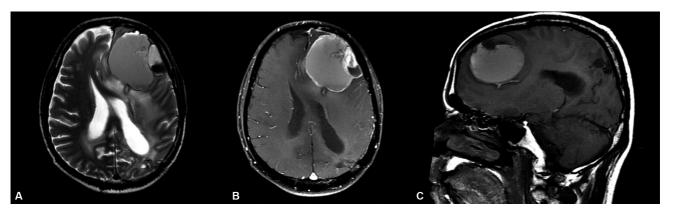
(A–C) Axial T2-weighted, post-contrast T1-weighted, and sagittal T1-weighted images post 4 weeks (on observation) showing an increase in the size of lesion and mass effect with cystic component now being T1 hyperintense and T2 intermediate.
